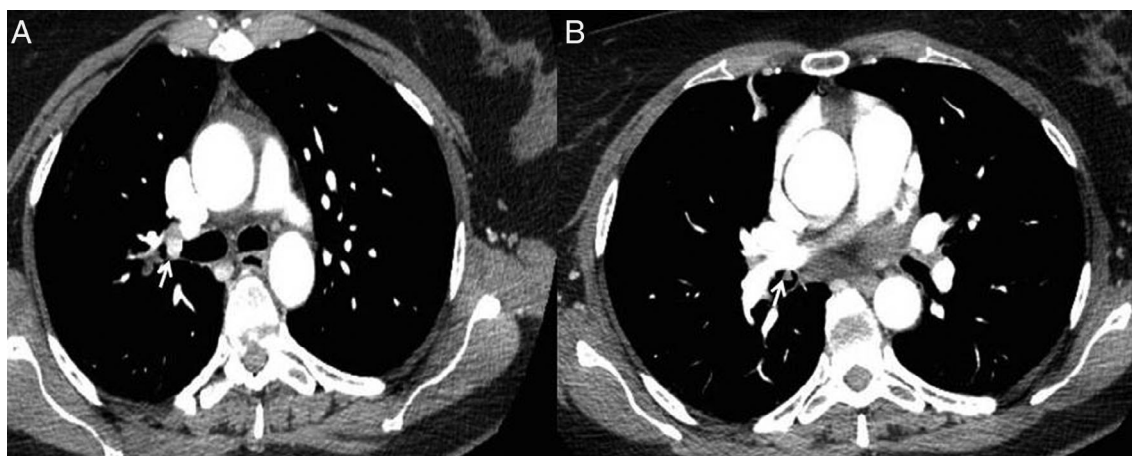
Contrast-enhanced chest computed tomography (CT) showed a vascularized round lesion with sub-occlusion of the upper right bronchus (A) and a triangular lesion on intermedium bronchus (B).
